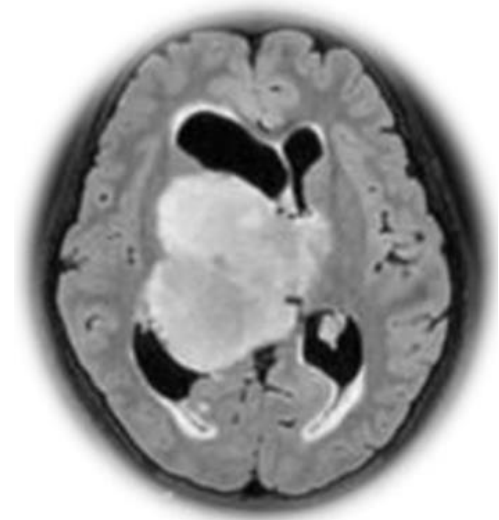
MRI FLAIR image showing the tumor mass (white in color) pushing the CSF inside the brain.
